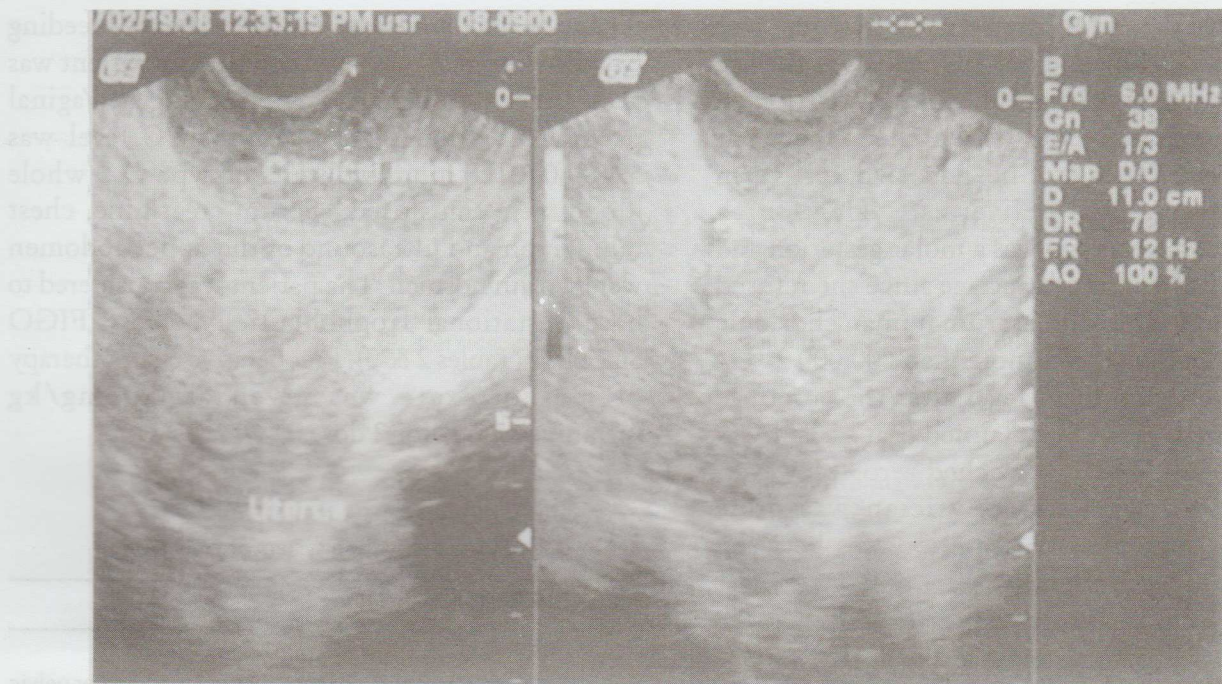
Transvaginal ultrasound of the uterus and cervical mass.
